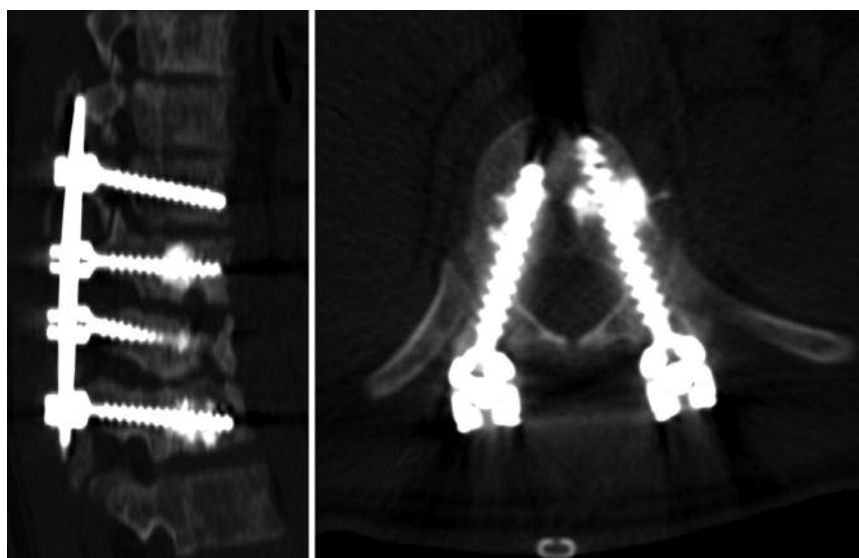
Post-operative sagittal and axial CT scan showing the bilateral artrectomy according to Ponte and posterior arthrodesis T10-L1 with fenestrated screws.
